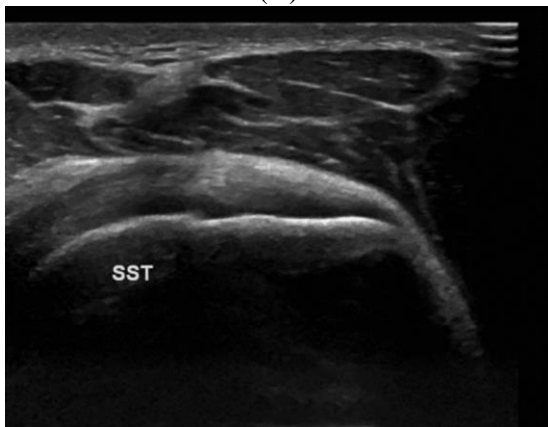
(A): Subscapularis tendinosis: Longitudinal ultrasound shows thickened and hypoechoic subscapularis tendon, (B): Supraspinatus partial tear: longitudinal ultrasound shows thickened supraspinatus tendon. Hypoechoic area is noted at the supraspinatus tendon (artistic), (C): Dynamic ultrasound view in adduction and abduction with internal rotation shows the sub-acromion tunnel measuring 0.98 and 0.47cm at the adduction and abduction with internal rotation position respectively, (D): Supraspinatus partial tear: Coronal (left image) and sagittal (right image) PD fat sat MRI shows intrasubstance high T2 signal intensity extending to its synovial surface with evolving extension to its bursal surface (arrow in left and artistic in right), (E): Acromioclavicular osteoarthritis and sub acromion bursitis: coronal PD fat sat MRI shows marginal osteophytes (small arrow). Small amount of high fluid signal is noted at the sub acromion space (large arrow).
